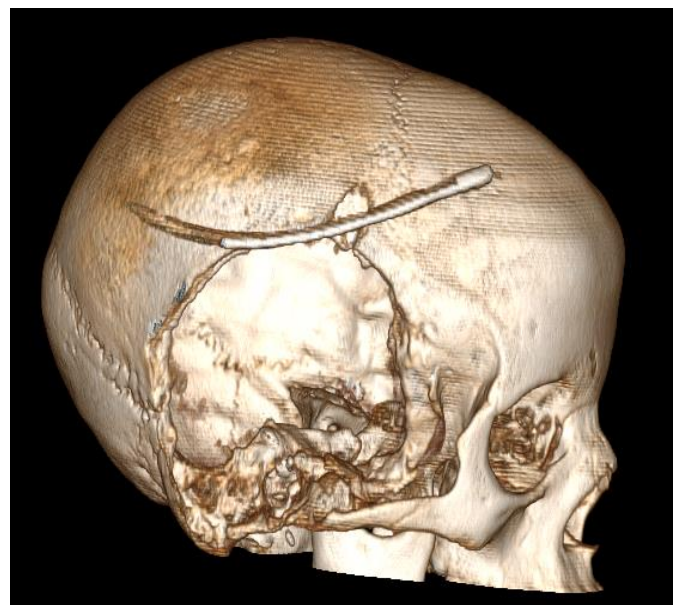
3D reconstruction of CT scan depicting cranial defect postoperatively
